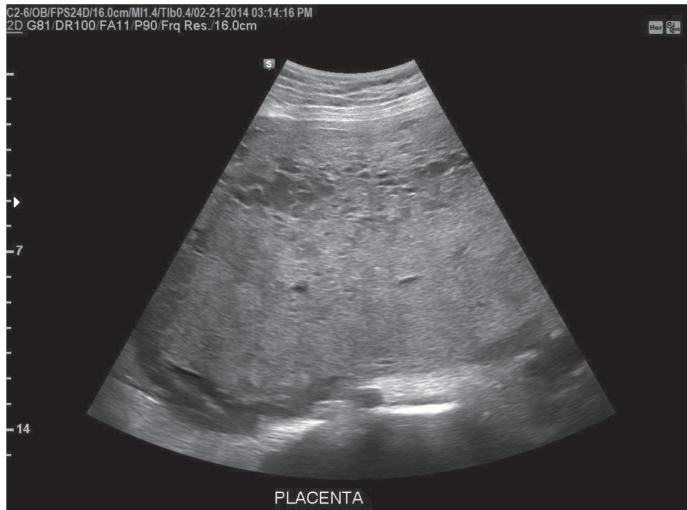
Ultrasound at 28 weeks and 2 days age of gestation: Enlarged placenta with multiple cystic spaces totally covering the os.
